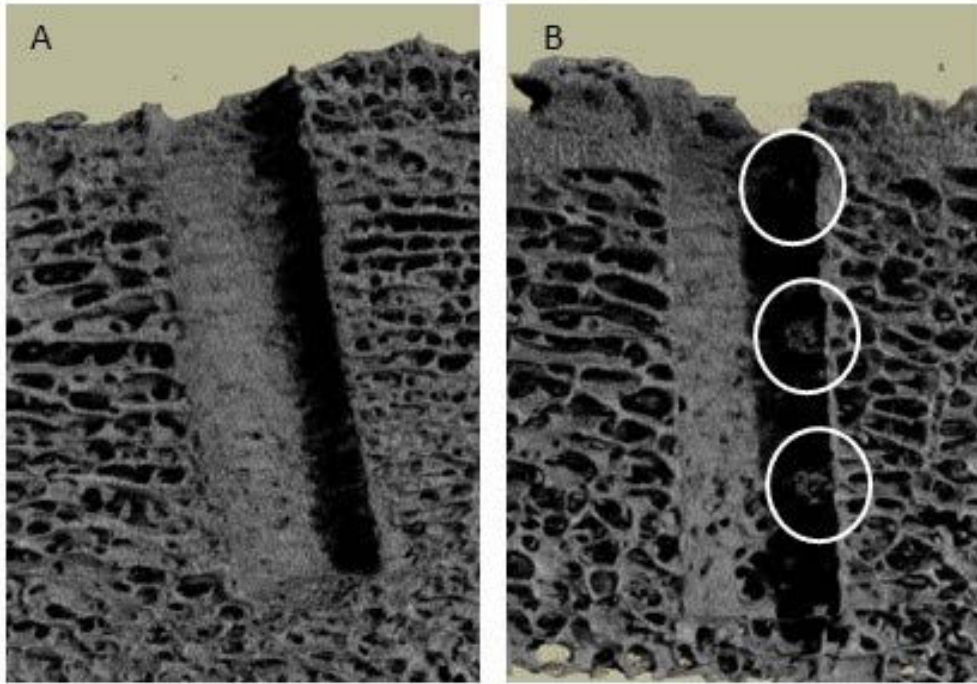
$\mu$ CT reconstruction of radiolucent PEEK and surrounding bone, control (A) and ANAB-treated PEEK (B). Bone growing into the gaps are seen on the ANAB-treated implants indicated by the white circles (B), which is absent with controls(A).
